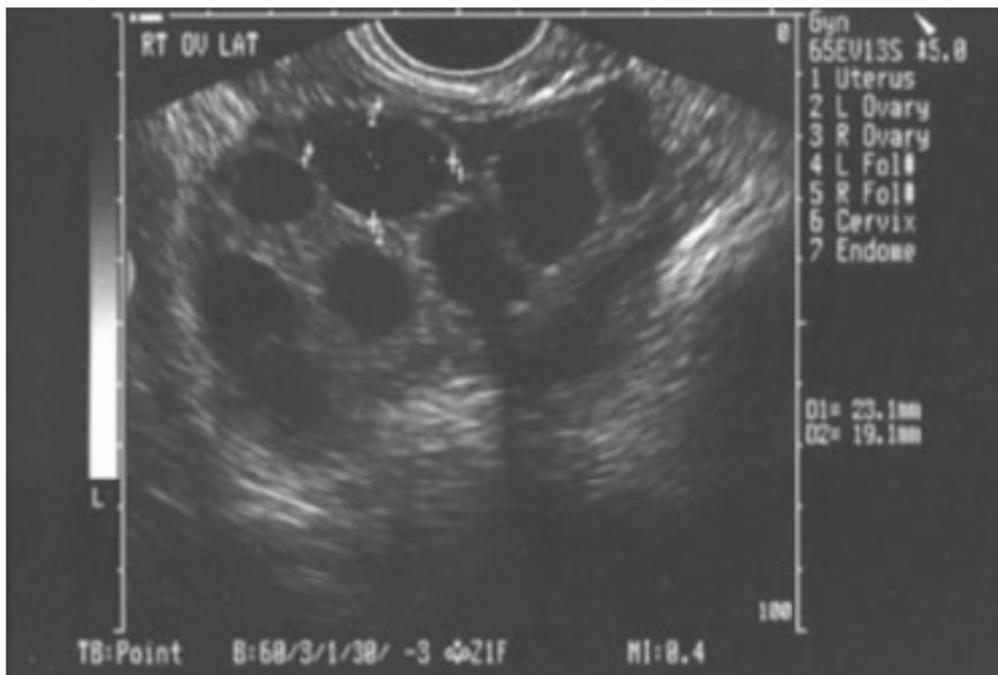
Ultrasound image of a hyperstimulated ovary with multiple follicles.
